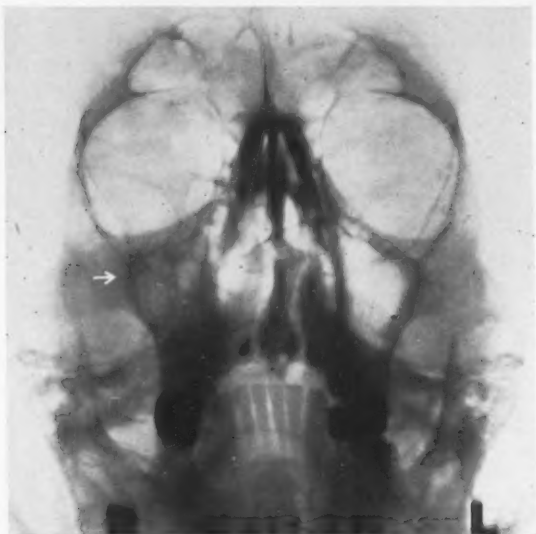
Roentgenogram showing marked cloudiness of right antrum. Antrum contained pus. Chronic arthritis of two years' duration. Marked improvement following antral irrigations.
